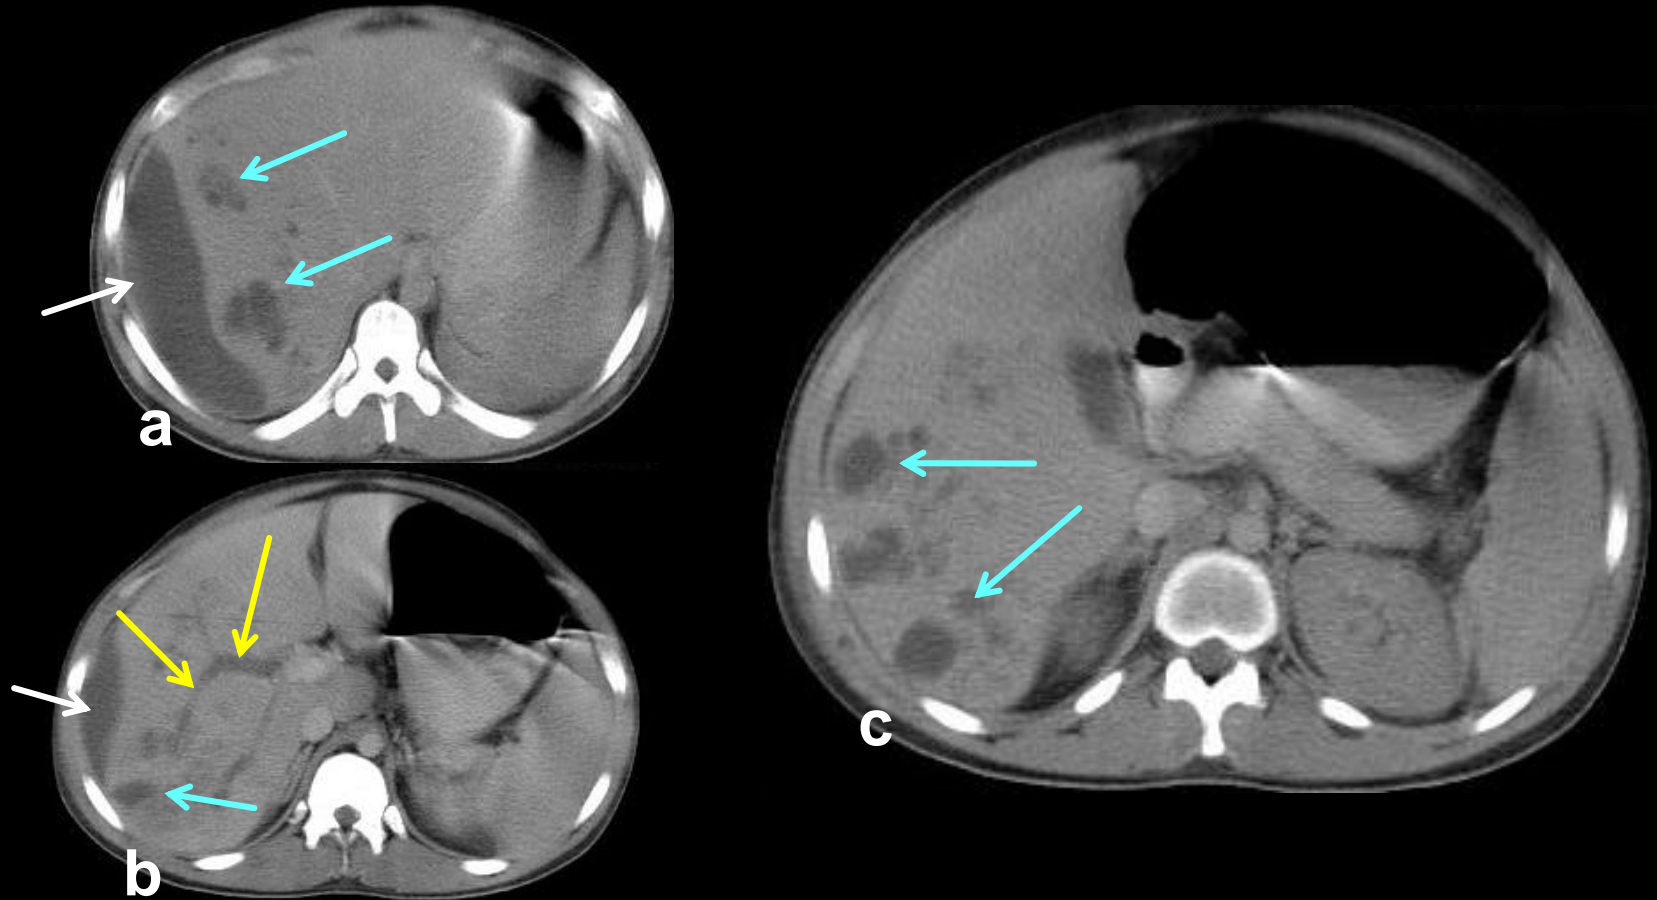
Transverse CT images (a,b,c) of a patient with septic thrombophlebitis of portal vein(yellow arrows) and associated pyogenic liver abscesses (blue arrows). A subcapsular collection was also present (white arrows). A direct cause of pylephlebitis was not found . A primary source of infection cannot be identified in 70% of patients.
